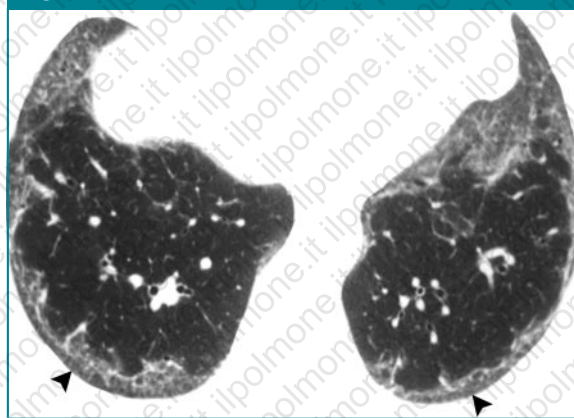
NSIP in 62-year-old woman. Transverse thin-section CT scan of basal segments of lower lobes shows peripheral GGO and mild reticulation with relative subpleural sparing (arrowheads) of lung immediately adjacent to pleura in dorsal lung regions. Note dorsal subpleural region is not normal but is less severely involved than region more than 1 cm away from pleura.
